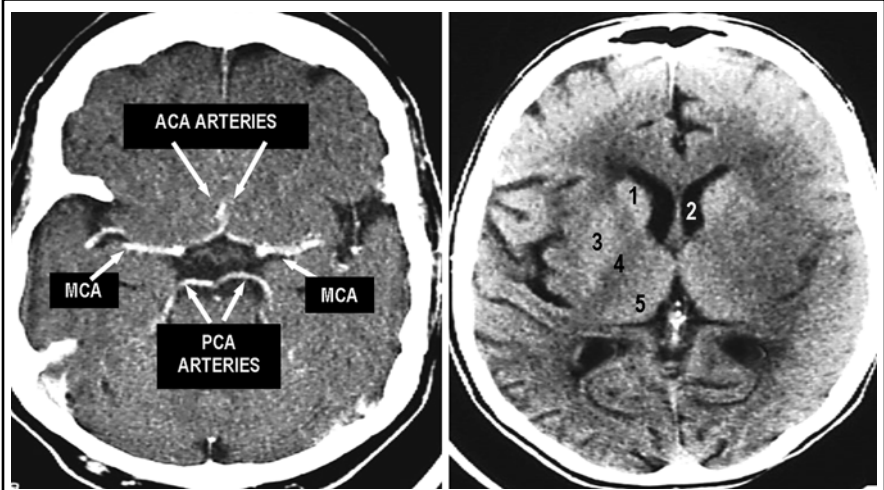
BASIC CT NEUROANATOMY
